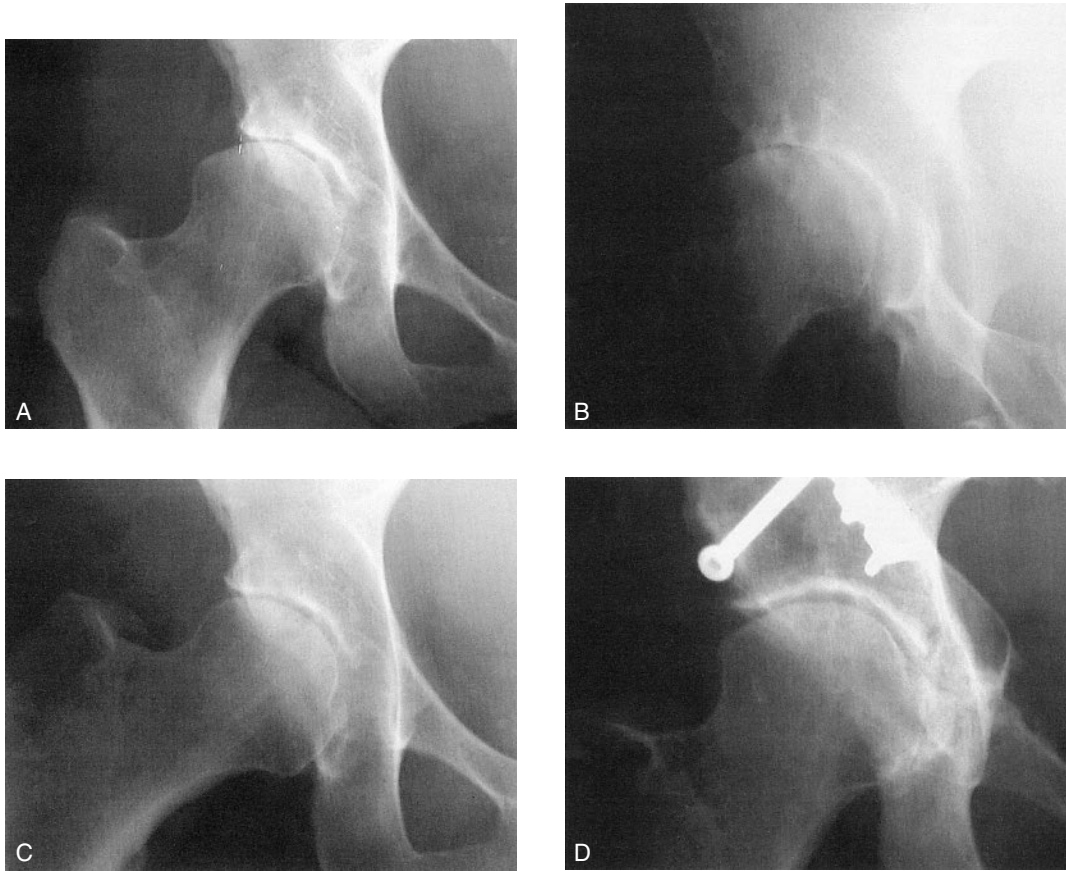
Anteroposterior radiograph of a 47-year-old woman with hip dysplasia shows cartilage interval narrowing, subchondral sclerosis, and cyst formation. (B) False profile view of the same hip shows focal bone-on-bone findings in the anterosuperior portion of the joint. (C) Anteroposterior radiograph of the hip in abduction shows spherical motion and an even cartilage interval. (D) Anteroposterior radiograph shows a well-maintained cartilage interval 10 years after acetabular redirection. The patient has a Harris hip score of 100 points.
